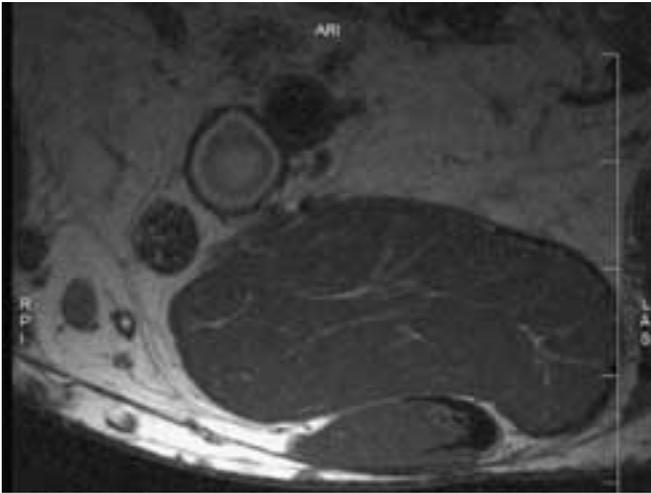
HR-MRI: T1W section to the popliteus; axial section of tibial nerve (diameter 0.6 mm).
